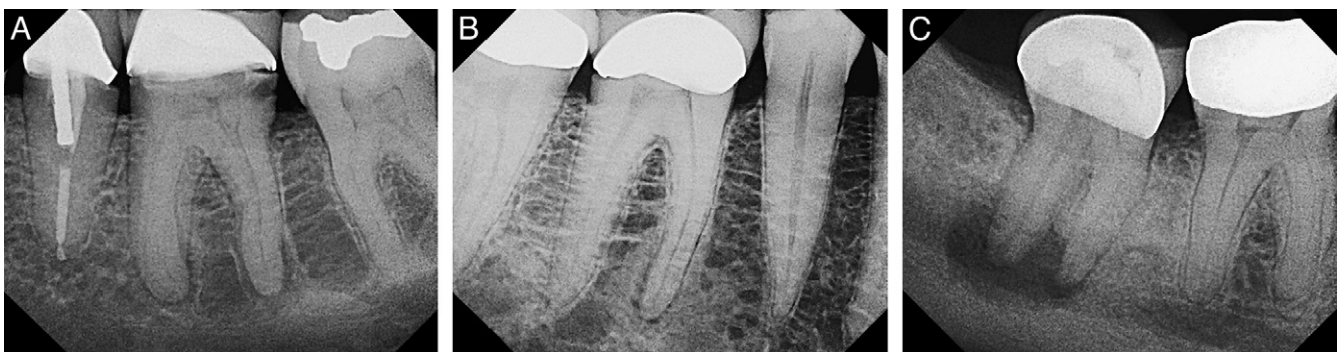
Examples of what could be referred to as a “periapical” lesion based on clinician interpretation and past educational and clinical experiences. (A) A radiograph of mandibular left first molar that exhibits, based on location, a “periapical” lesion or radiolucency at the apex of the mesial and distal roots. The distinction in the use of the term “periapical” versus “apical” would be based on the position of the radiolucencies that are located both apically and 3 to 4 mm coronally or “periapically” around the root end. (B) A radiograph of mandibular right first molar that exhibits, based on location, a “periapical” lesion or radiolucency at the apex of the mesial and distal roots. Although some clinicians may describe this as a thickened periodontal ligament space on the mesial, the width of the ligament space far exceeds that of 2 mm, which is considered as an acceptable criteria. (C) A radiograph of mandibular right second molar that exhibits, based on location, a “periapical” lesion or radiolucency at the apex of the mesial and distal roots. Some clinicians may describe this as a “periradicular” lesion because of its extensive encompassing of the root structure.
